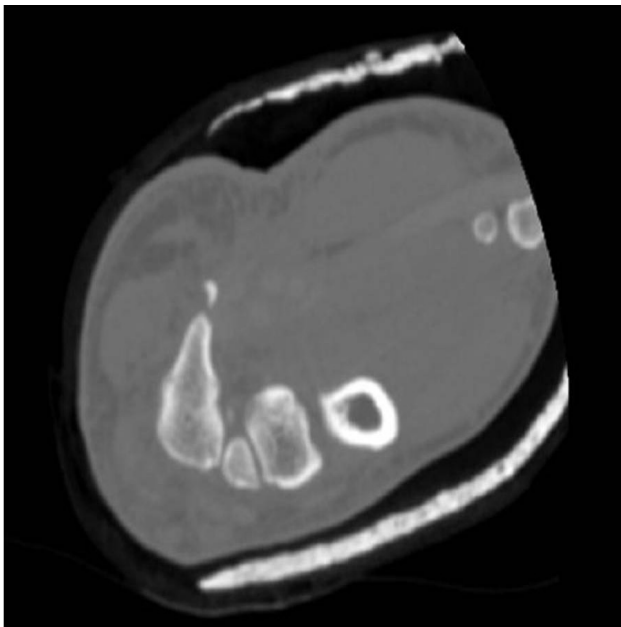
Axial (A) and sagittal (B) computed tomography images of an ossicle or fracture of the tip of the hook of the hamate.
